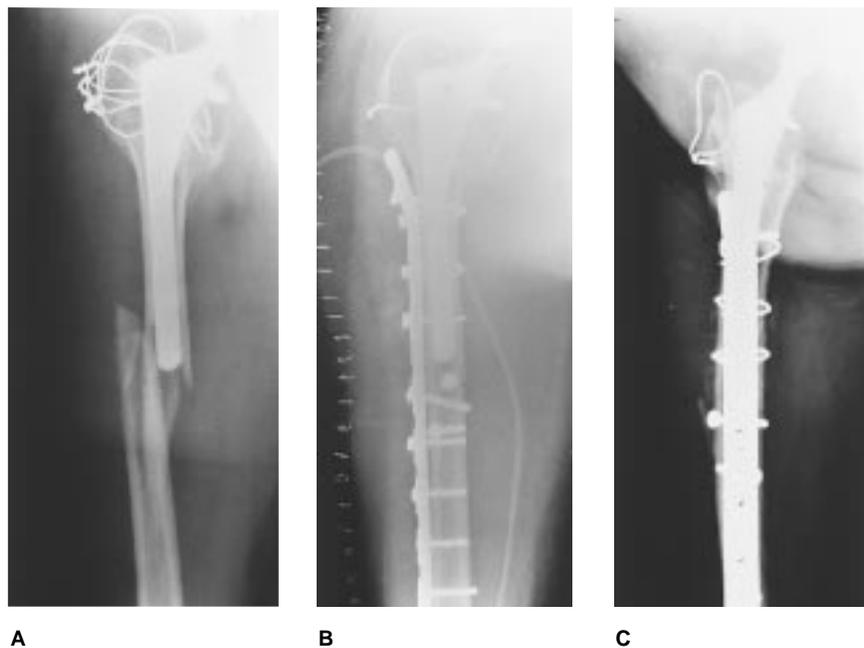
Images of a 42-year-old hemophilic patient with a dysplastic hip who had undergone noncemented total hip arthroplasty 6 months earlier because of severe pain. A, Severe trauma to the leg resulted in a combination middle- and distal-region fracture that did not involve the proximal porous coating of the prosthesis. B, Postoperative anteroposterior radiograph shows fixation with modified plate for screw-and-cerclage fixation. Note that there is room for only one proximal screw in the intertrochanteric region. C, Frog-leg lateral radiograph obtained 6 months after open reduction and internal fixation (1 year after total hip arthroplasty) shows evidence of fracture healing. Full weight-bearing without pain was possible.
